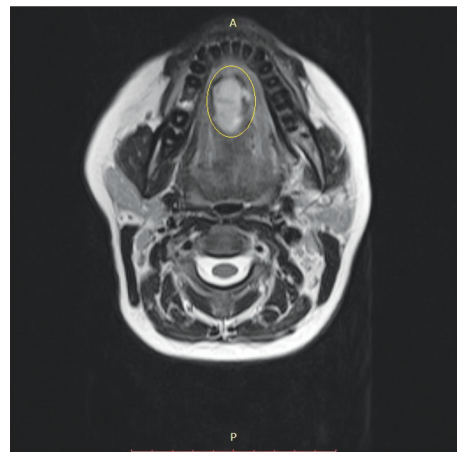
T2-weighted axial magnetic resonance imaging shows a hyperintense lobulated contoured abscess within the yellow ring.
